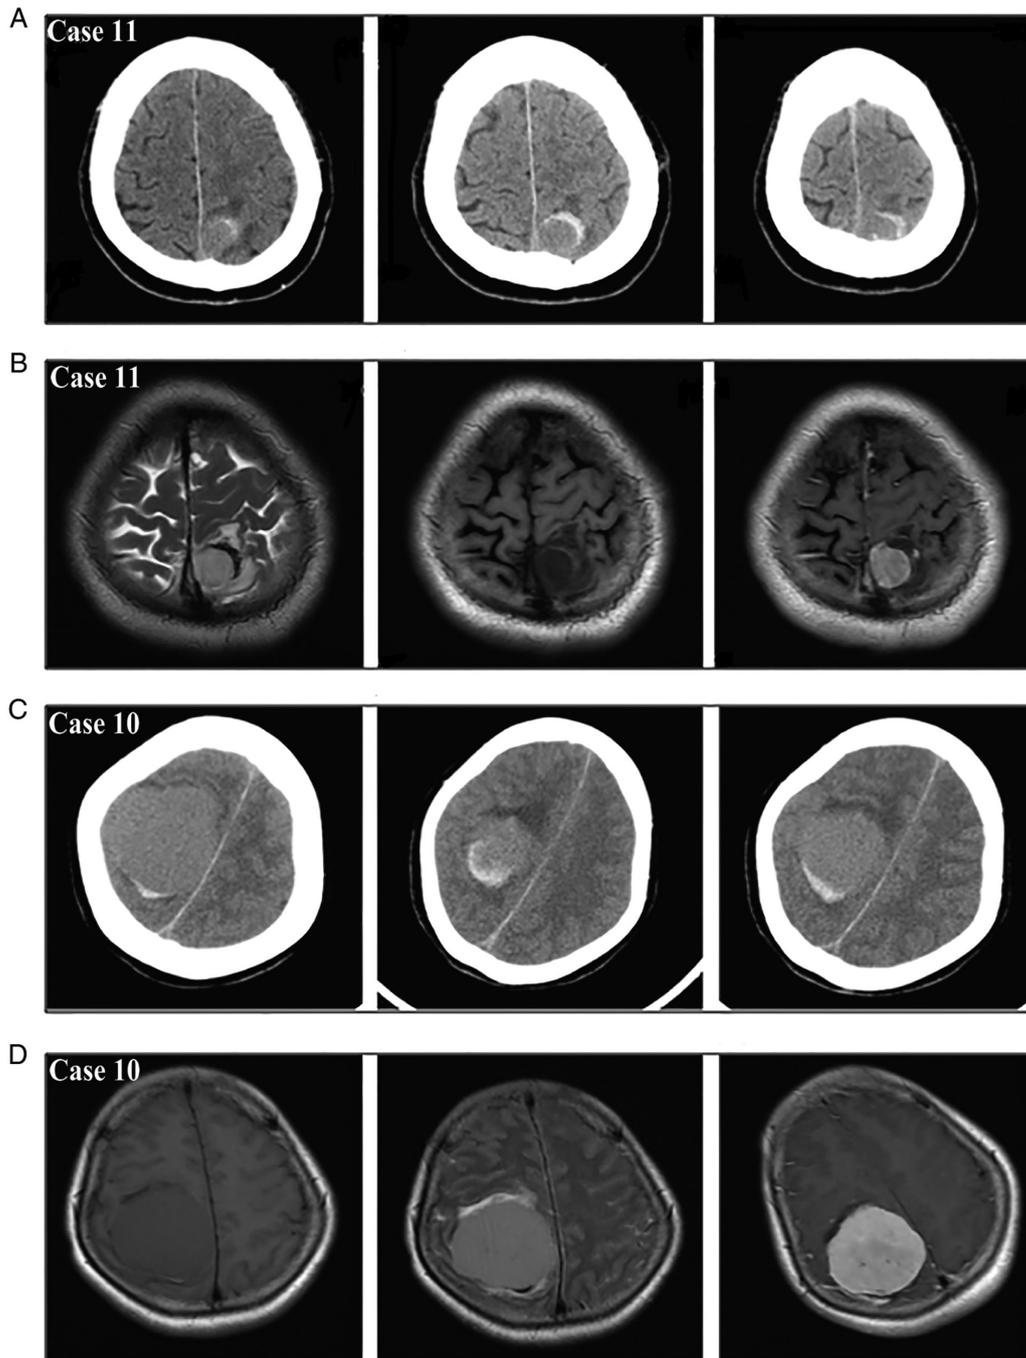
Neuroimaging findings for (A and B) representative case 11 and (C and D) case 10 with purely extratumoral hemorrhage. Preoperative brain computed tomography showing (A) a round iso-dense extra-brain mass with peritumoral hemorrhage in the left parasagittal region of case 11 and (C) a round iso-dense extra-brain mass with peritumoral hemorrhage in the right parietal area of case 10. Magnetic resonance imaging further showing (B) an extra-brain mass in the left parasagittal region of case 11 and (D) an extra-brain mass in the right parietal area of case 10 respectively, which were homogeneously enhanced and had acute peritumoral hematoma.
